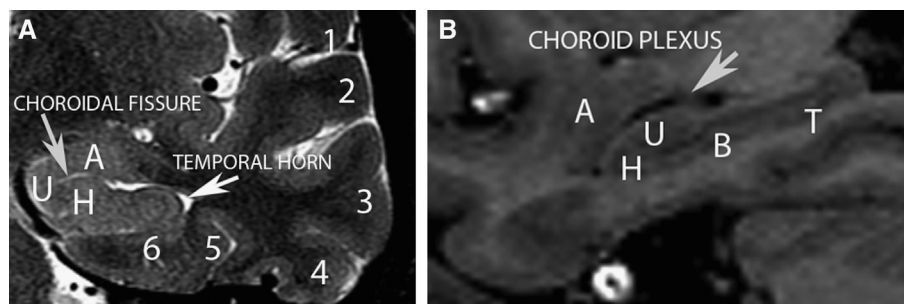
Imaging anatomy of temporal lobe. Coronal T2-weighted (A) and sagittal T1 3-dimensional inversion recovery (B) images, showing mesial temporal lobe structures: sylvian fissure (1); superior (2), medial (3), inferior (4) temporal gyri; parahippocampal gyrus (5); collateral white matter (6); uncus (U); amygdala (A); and head (H), body (B), and tail (T) of the hippocampus.
